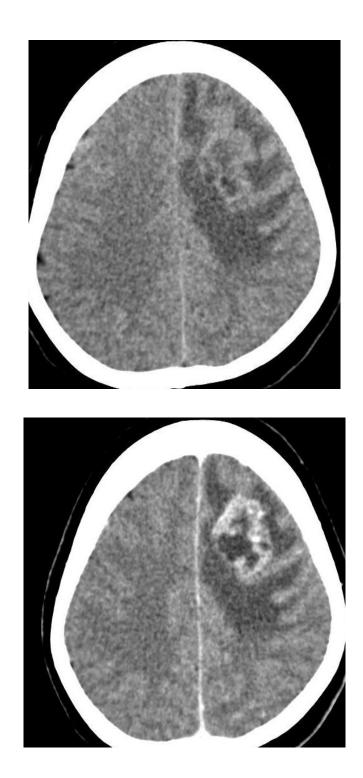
Solitary lesion with necrotic core in left frontal lobe with perilesional edema, in a patient with carcinoma of lung. MRI confirmed metastatic lesion.
